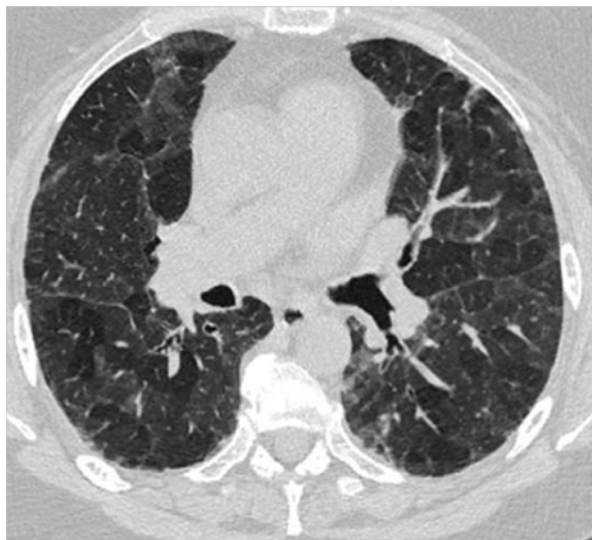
The typical radiographic appearance of chronic hypersensitivity pneumonitis with peribronchiolar infiltrates and mosaic appearance from air trapping
